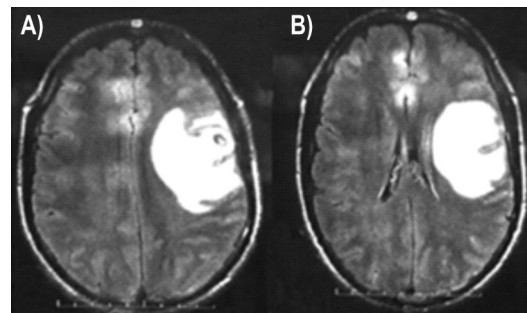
Magnetic resonance imaging (MRI) of the brain at admission at Kharkiv city Students Hospital on 26 November 2019. A, B) On both slides in frontal section at different degrees of depth the lateral part of the left frontal lobe is depicted with the presence of cortical-subcortical inhomogeneous structure with volume formation, irregular shape, without clear outlines of 24x26x25 mm size with a pronounced perifocal oedema and mass effect with compression of the left lateral ventricle and shift of midline structures to the right by 3mm
